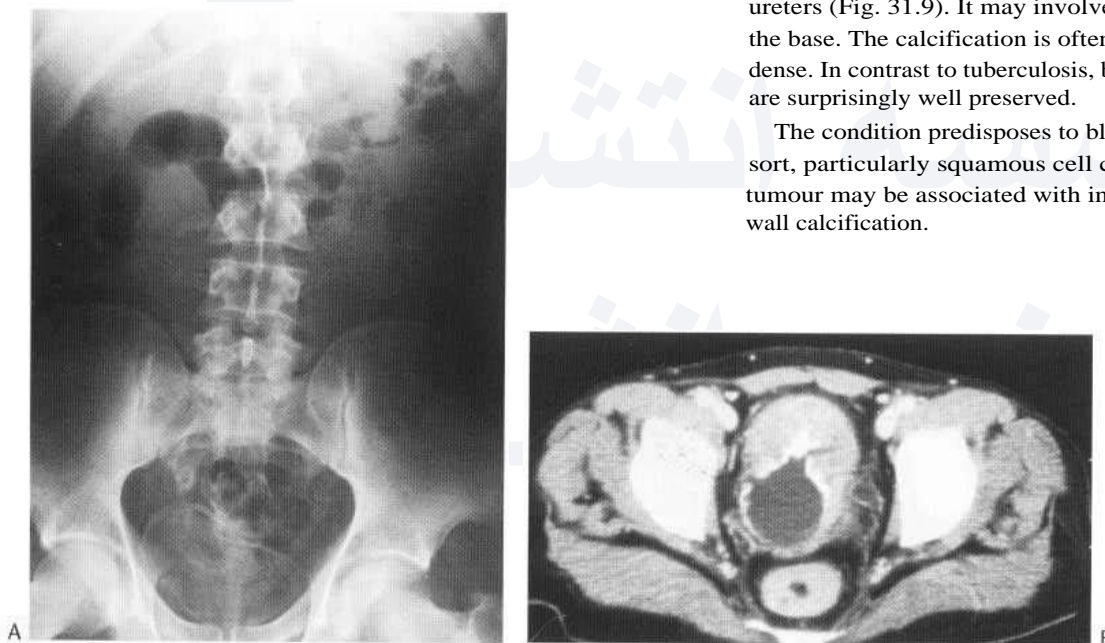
Plain film (A) showing linear calcification along the bladder wall and distal left ureteric walls. CT (B, different patient) is highly sensitive for the demonstration of bladder wall calcification and will also show the soft-tissue wall thickening which may be gross and (as here) associated with rectal wall thickening. (Courtesy of Dr Shadley Fataar of the Royal Hospital, Muscat, Oman.)
